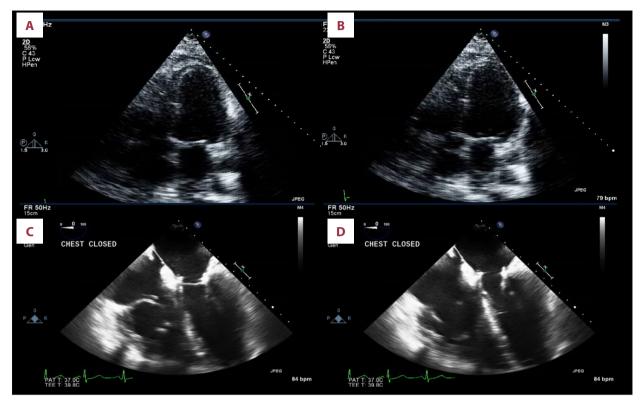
(A, B) Postoperative transthoracic echocardiogram showing that the mass is now absent, with right ventricular systolic pressure improved to 50 mmHg. (C, D) Perioperative transesophageal echocardiogram confirming removal of echodensity and mild improvement of the left ventricular ejection fraction to 45-50%.
